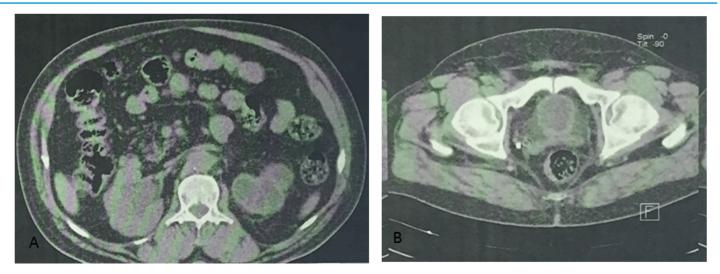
CT cross section.
